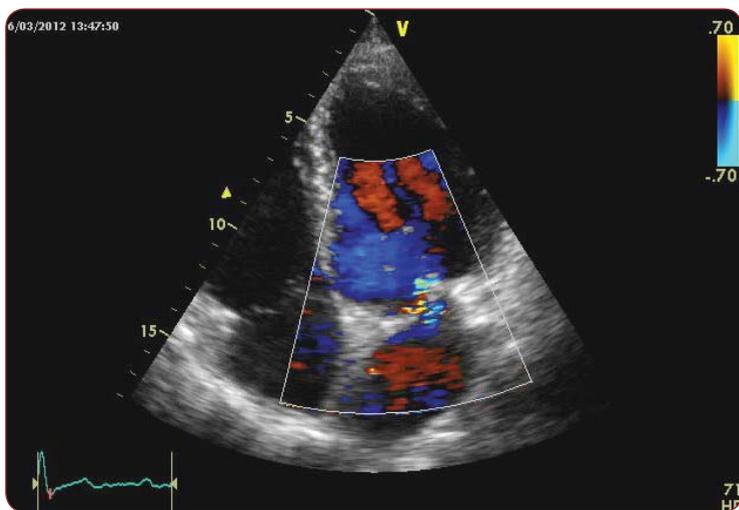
Transthoracic echocardiogram, four chambers apical section with color Doppler at the mitral valve, showing mild residual regurgitation.
